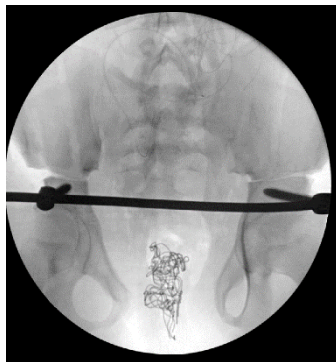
Clinical (A) and radiographical (B, C, D) demonstrations of access point at the AIIS area and placement of the multi-axial pedicle screw
